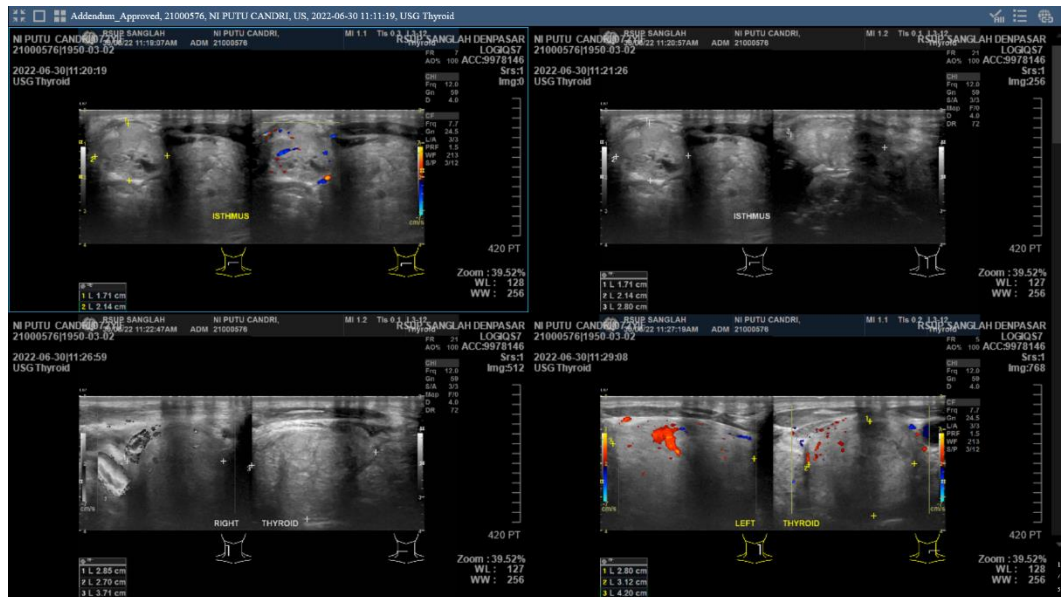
Result of thyroid ultrasound
